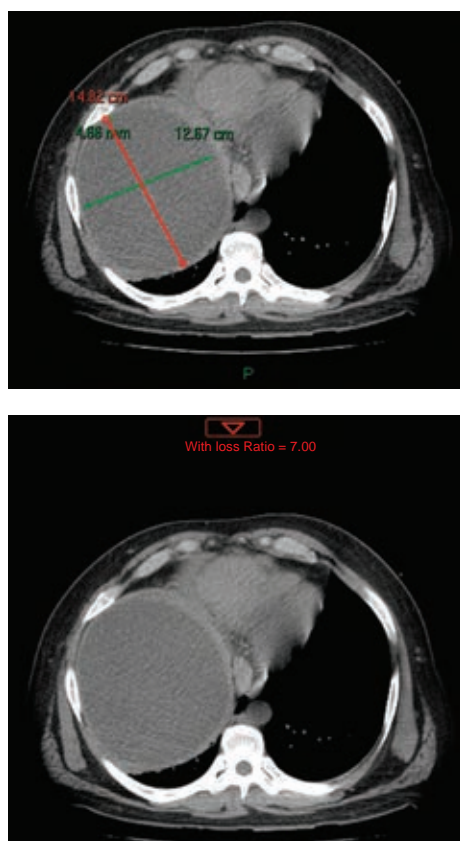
Thorax and abdomen simple computed tomography scan. Axial section taken 48 hours later showing no volume increase.
